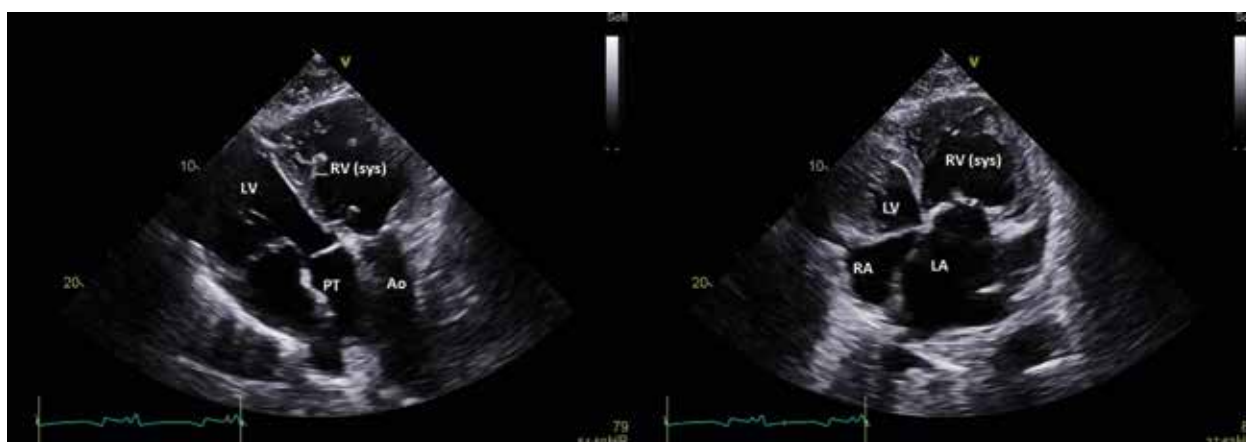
Echocardiographic examination, substernal projections. Enlarged, spherical right ventricle with myocardial hypertrophy, with significant impairment of contractility (ejection fraction 30%). Great arteries arising from the heart with a parallel course characteristic of congenitally corrected transposition of the great arteries; Ao — aorta; LA — left atrium; LV — left ventricle; PT — pulmonary trunk; RA — right atrium; RV (sys.) — right ventricle (systemic)
